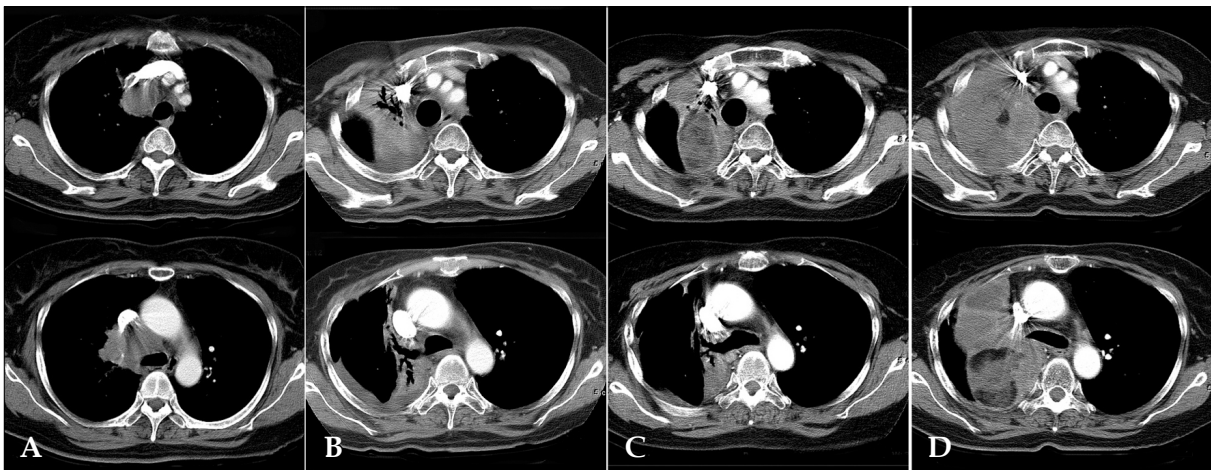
Serial chest CT scans: (A) At the time of the small cell lung cancer diagnosis (Nov. '99); (B) Only radiation pneumonitis existed ten months after thoracic radiation therapy (Oct. '00); (C) A new mass with fat density was detected (Nov. '01); (D) A slow growing mass with fat density and another new mass replacing the right upper lobe (Oct. '03).
